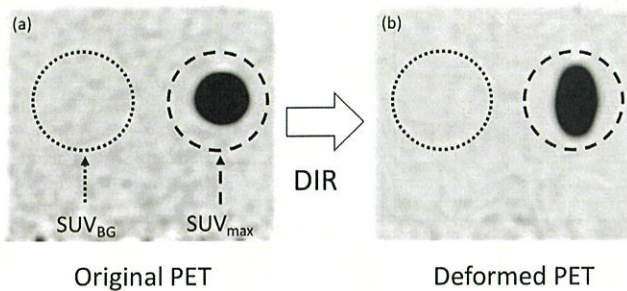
(a) The PET images of the S38 and (b) deformed PET images applied to the insert of A. The SUV_{max} and SUV_{BG} were obtained from the VOI of the dashed line and dotted line.
